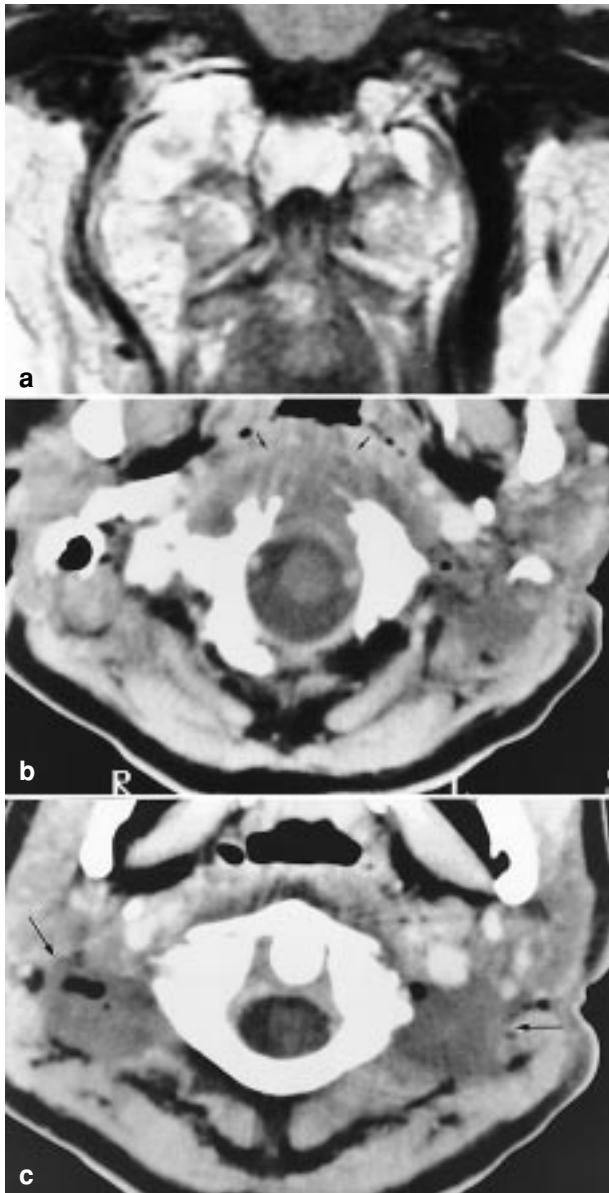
Bilateral chordoma. (a) Pre-operative MRI (coronal view). (b and c) Post-operative CT scanner at the level of the condyle (b) and of the atlas (c). The arrows indicate the areas of resection
